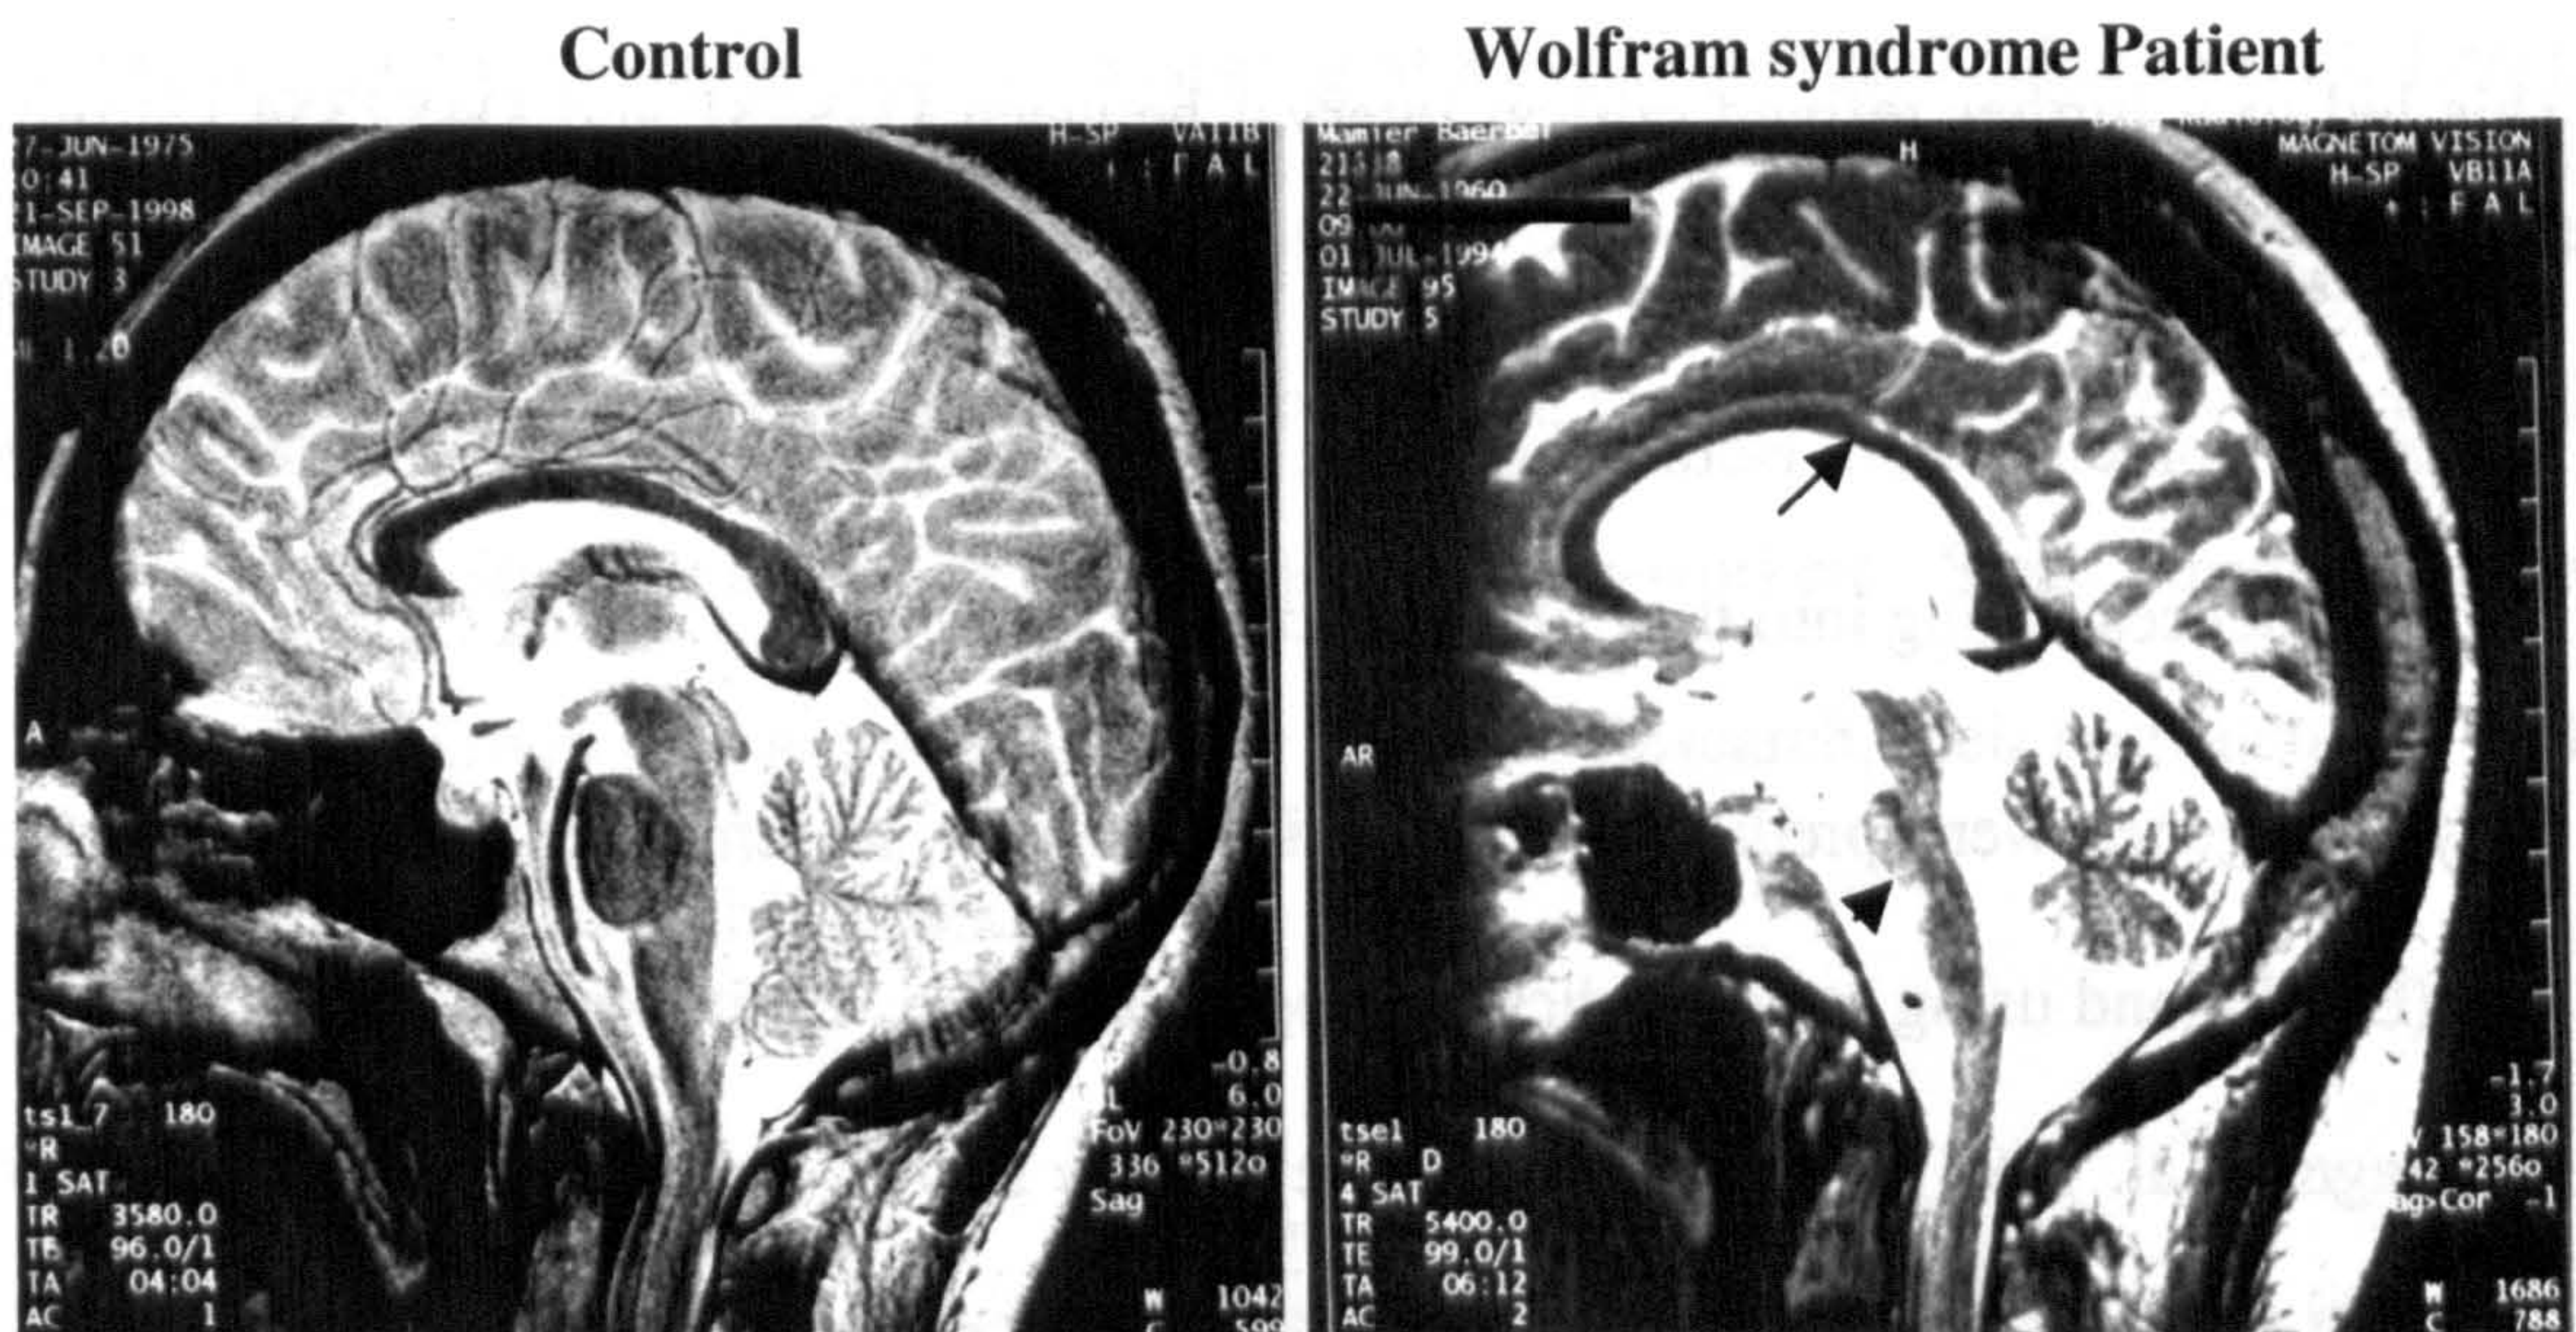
MRI of a control person and a Wolfram patient. In the patient sample, a generalized brain atrophy, pronounced atrophy of the cerebellum (arrow) and atrophy of the brain stem (arrow head) can be seen. Also of note are an absence or reduced signal in structures of the limbic system.
